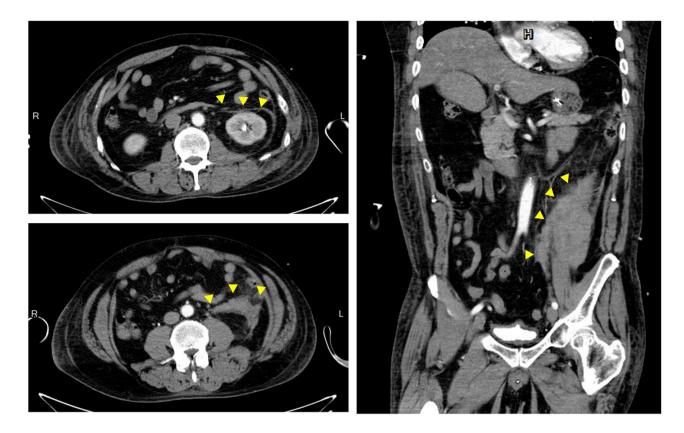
Repeat contrast-enhanced CT of the abdomen on POD 4. Regressive change was noted in comparison to findings in the prior CT (Fig. 1): yellow arrowheads
